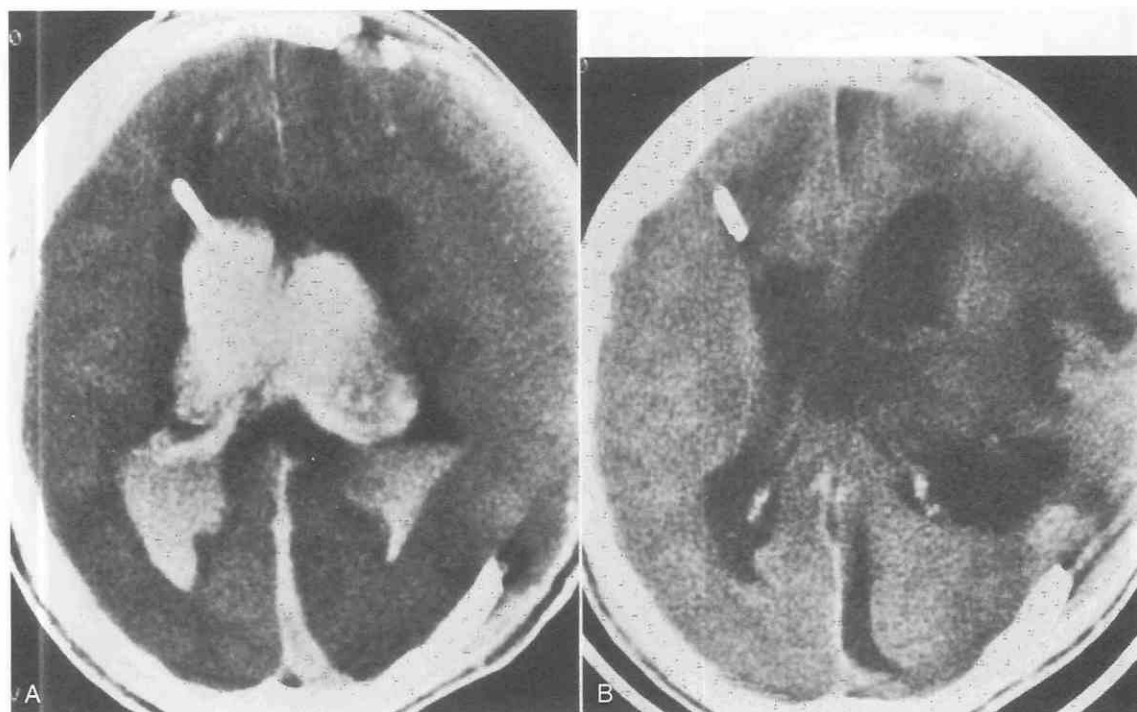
A, Hydrocephalus. Axial CT scan shows ventricular enlargement with massive intraventricular hemorrhage. A shunt tube is present in the right lateral ventricle. Posterior interhemispheric subdural hematoma and frontal lobe contusions are present. B, Ten days later, the intraventricular hemorrhage has resolved, and the ventricles have decreased in size but remain enlarged.
